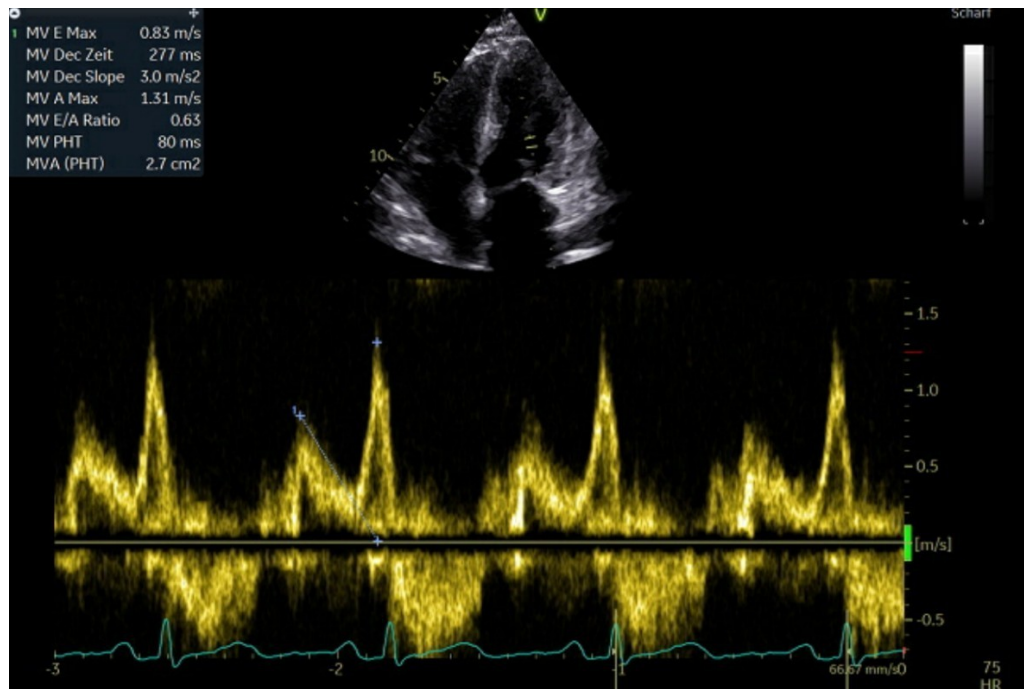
E- and A-wave in a pulse-wave Doppler view; Example of a patient with a diastolic dysfunction with an E/A ratio of 0.63; MV, mitral valve; E Max, maximal velocity of the E wave; Dec Zeit, deceleration time, Dec Slope, deceleration slope, A Max, maximal velocity of the A wave; MV PHT, Mitral Valve Pressure Half Time, MVA (PHT), Mitral Valve Area by Pressure Half Time; HR, heart rate
